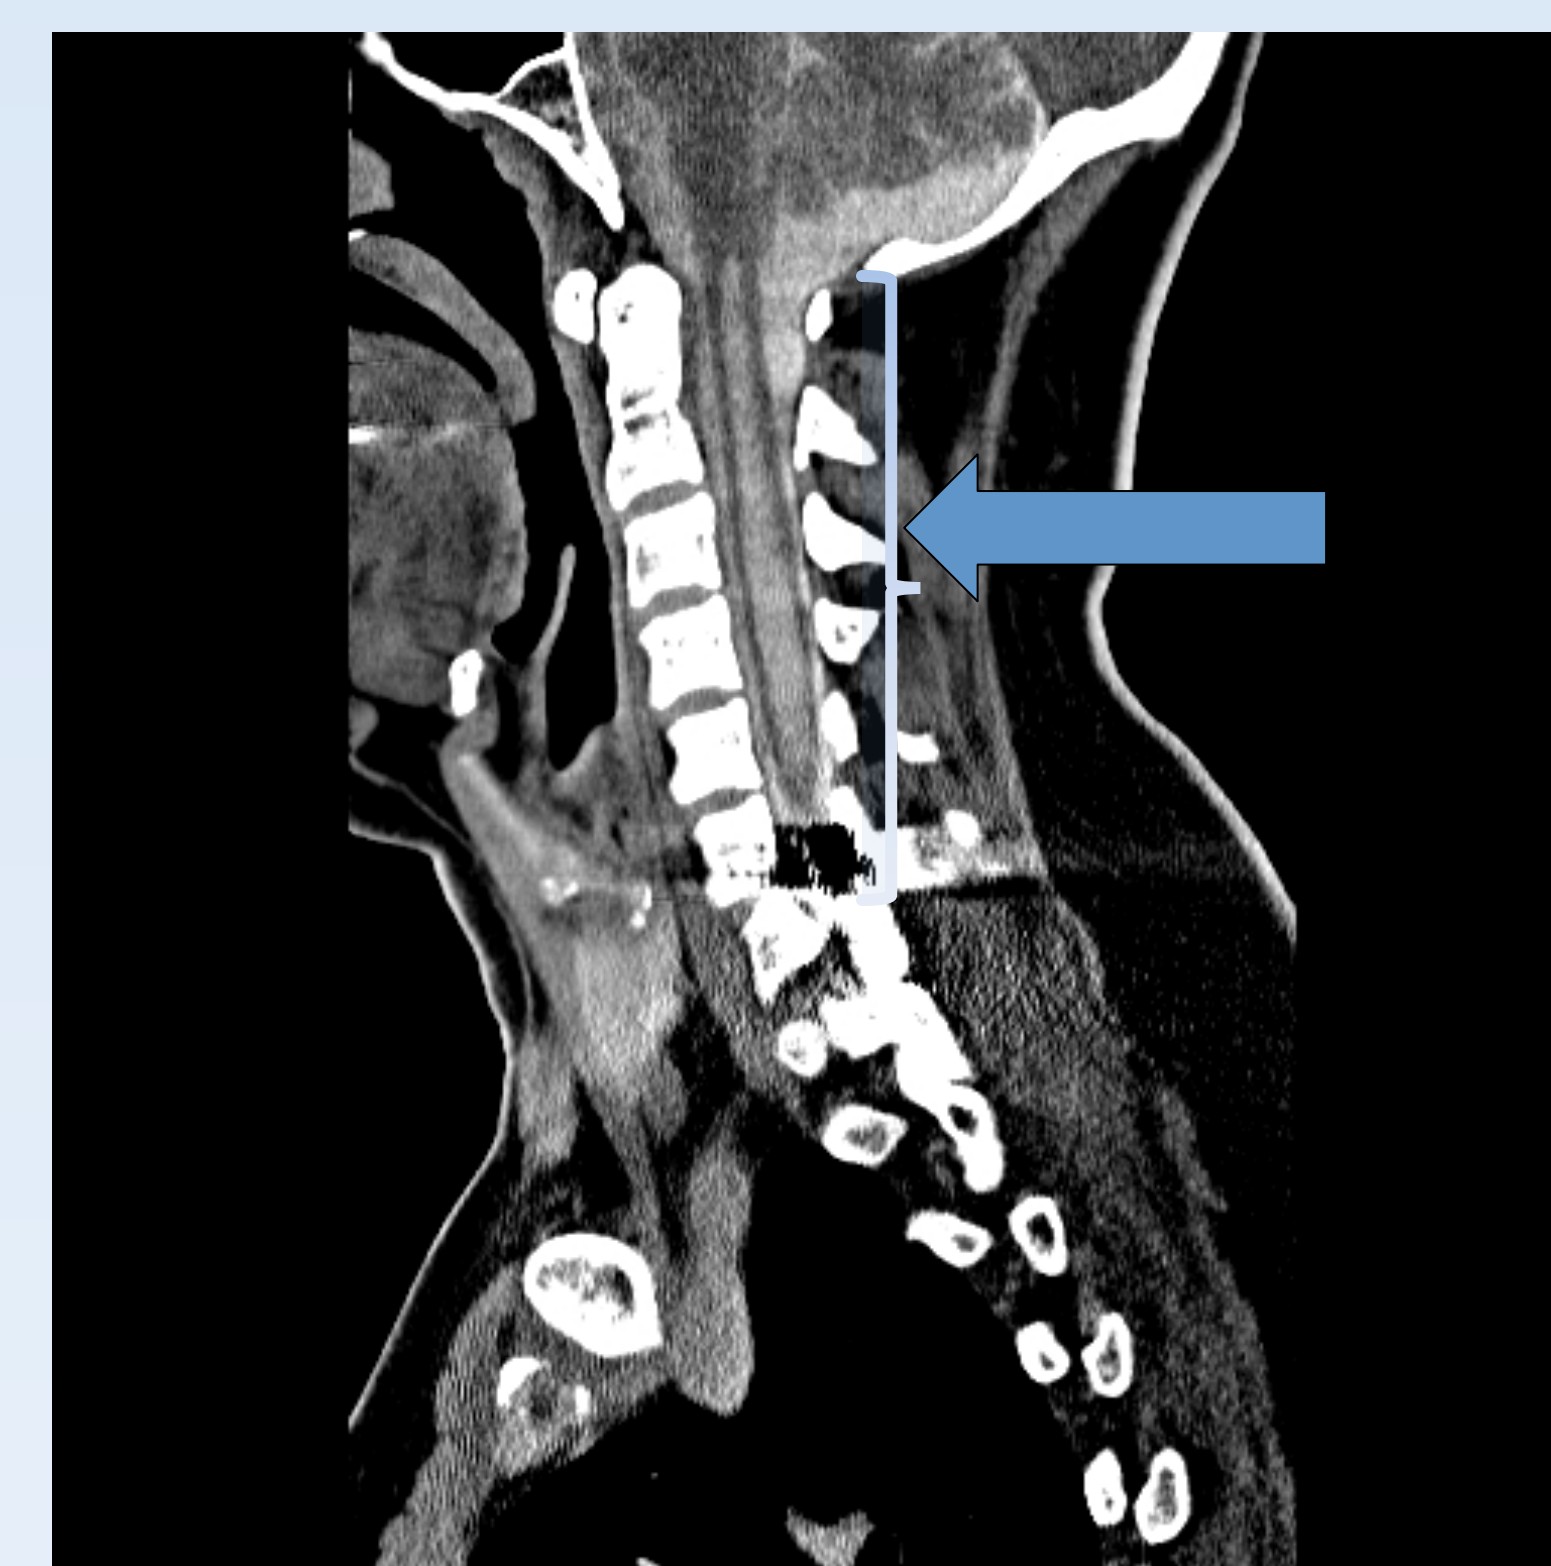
Delayed CT Myelogram
